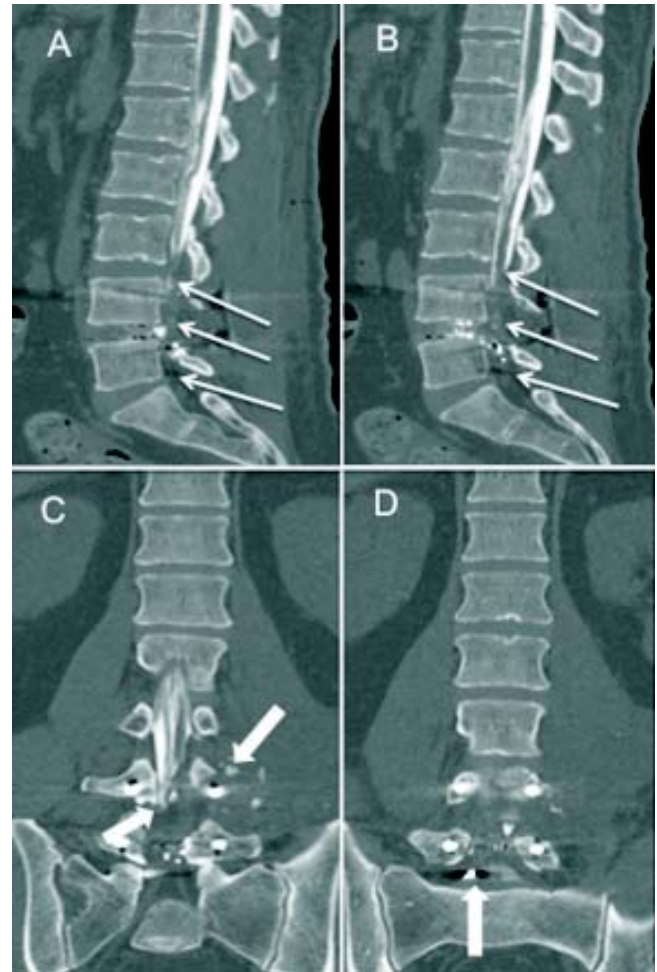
Postoperative CT-myelography with multiplanar reconstructions. A and B. Sagittal plane images show the interruption of the CSF at the L4 level in the sagittal plane (white narrow arrows). C and D. Coronal plane depicting the interruption of the *cauda equina* and the presence of bone fragments outside the spinal canal with one residual splinter from the handgun inside the spinal canal at the L4-L5 levels (thick white arrows).
